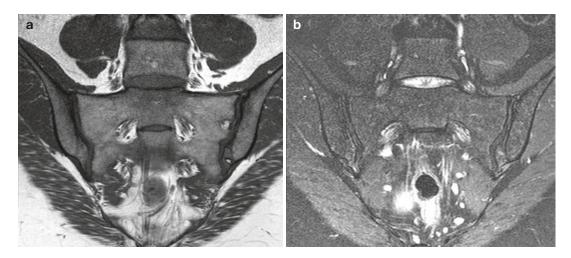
MRI of the sacroiliac joints. (a) Cor T1; note marrow signal intensity is heterogenous and lower than Fig. 3.41a due to hematopoietic tissue. (b) Cor T2FS
